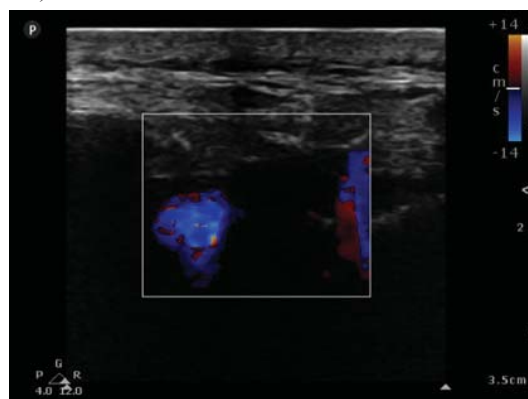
Caudal block under ultrasound guidance.
